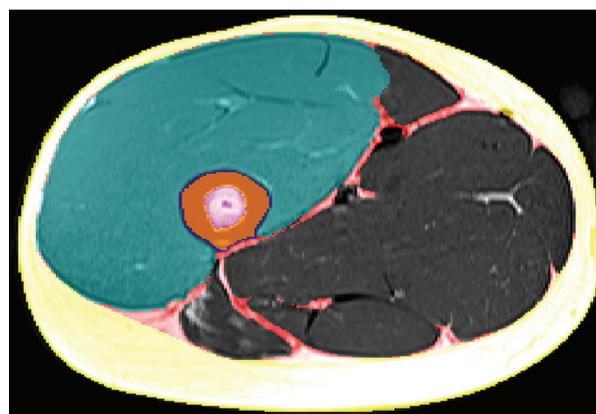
Axial thigh MRI scan showing the segmentation of total femoral bone (blue boundary), cortical bone (orange area), quadriceps muscle (green area), intermuscular fat (red area), and subcutaneous fat (yellow area).
